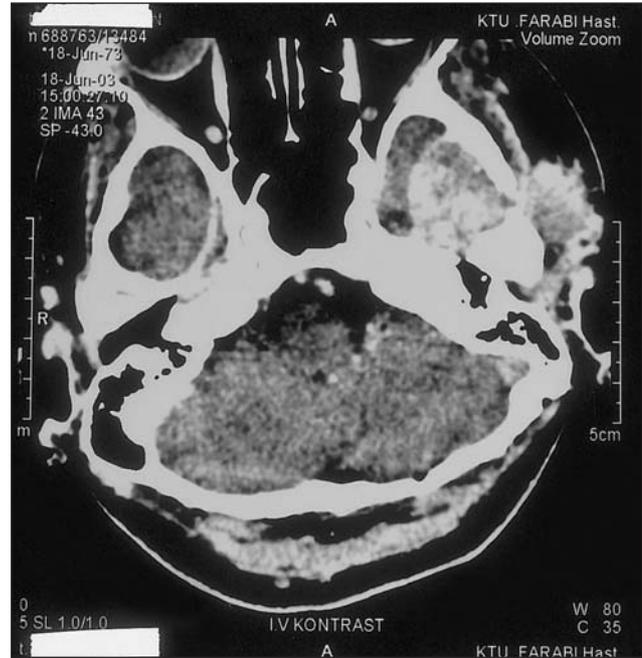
Postcontrast axial CT scan of giant cell tumor before operation showed a mass expanding the squamous and petrous sections of the left temporal bone.
